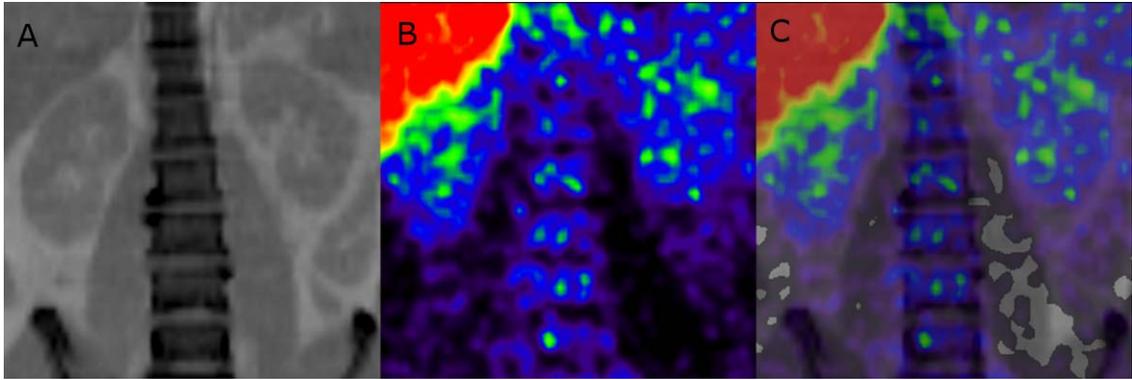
Typical example of coronal slices of (A) CT, (B) PET, and (C) PET/CT.
